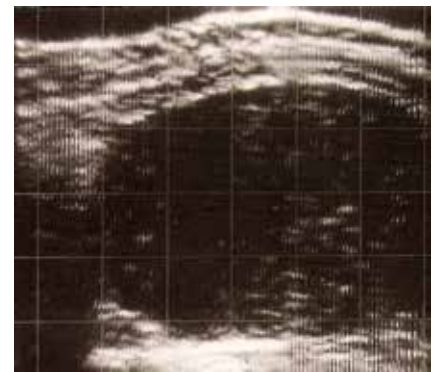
Sonogram of a solid malignant ovarian tumor. Clearly visible internal structures of the tumor at a low amplifier threshold. The distance between the grid lines on this and on the following figures correspond to 2 cm within the body.
